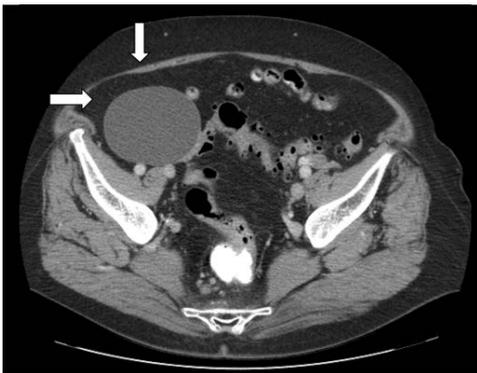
CT image showed the right cyst ovary (diameter 80 mm).
